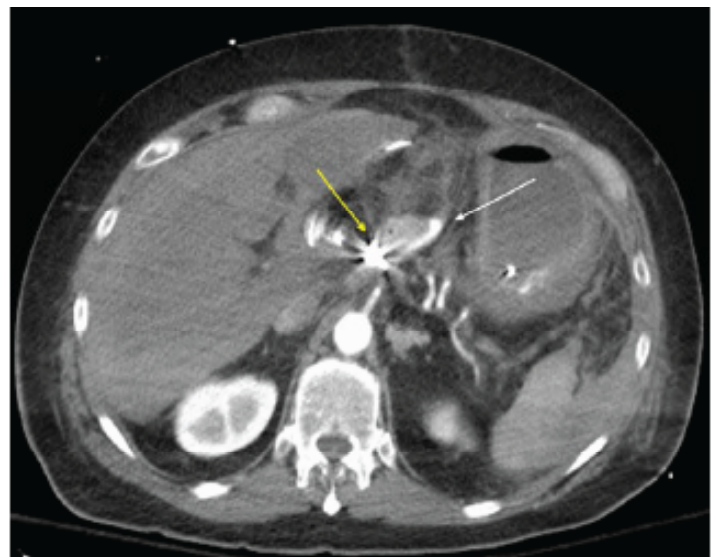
Axial computed tomography image in early arterial phase following angiography with endovascular coil embolization of the proximal common hepatic artery (single yellow arrow). There is noted absent arterial flow within the liver due to lack of replaced hepatic arterial flow. Previous extravasated contrast within the peritoneal cavity is shown (single white arrow) from the preceding angiography study.
